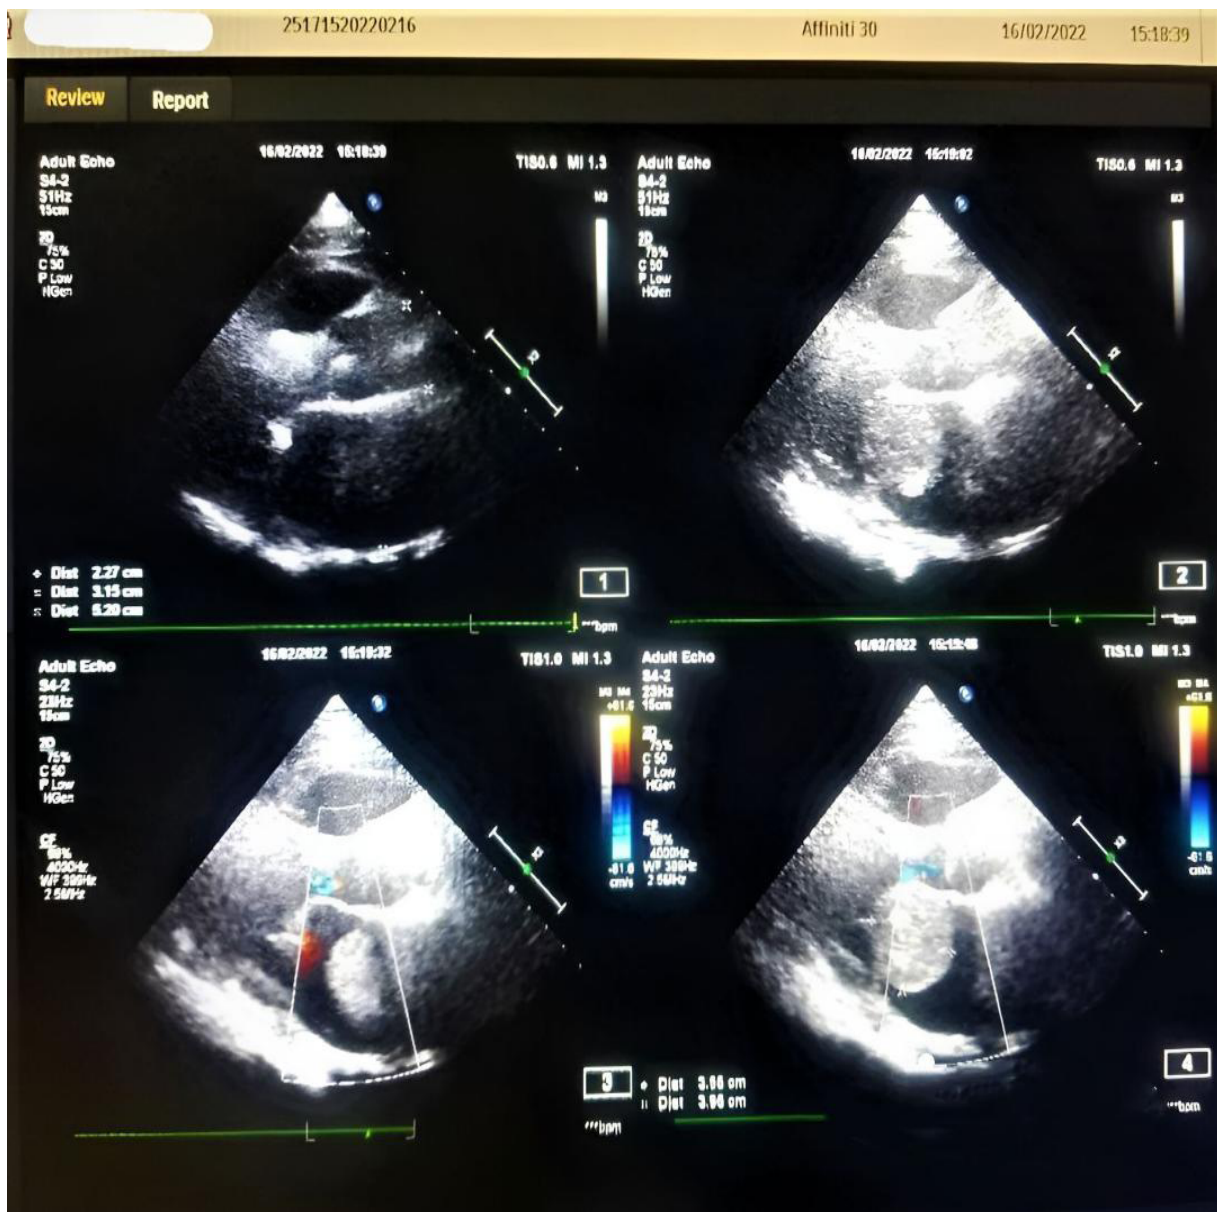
Transthoracic Echocardiography, parasternal long axis view
